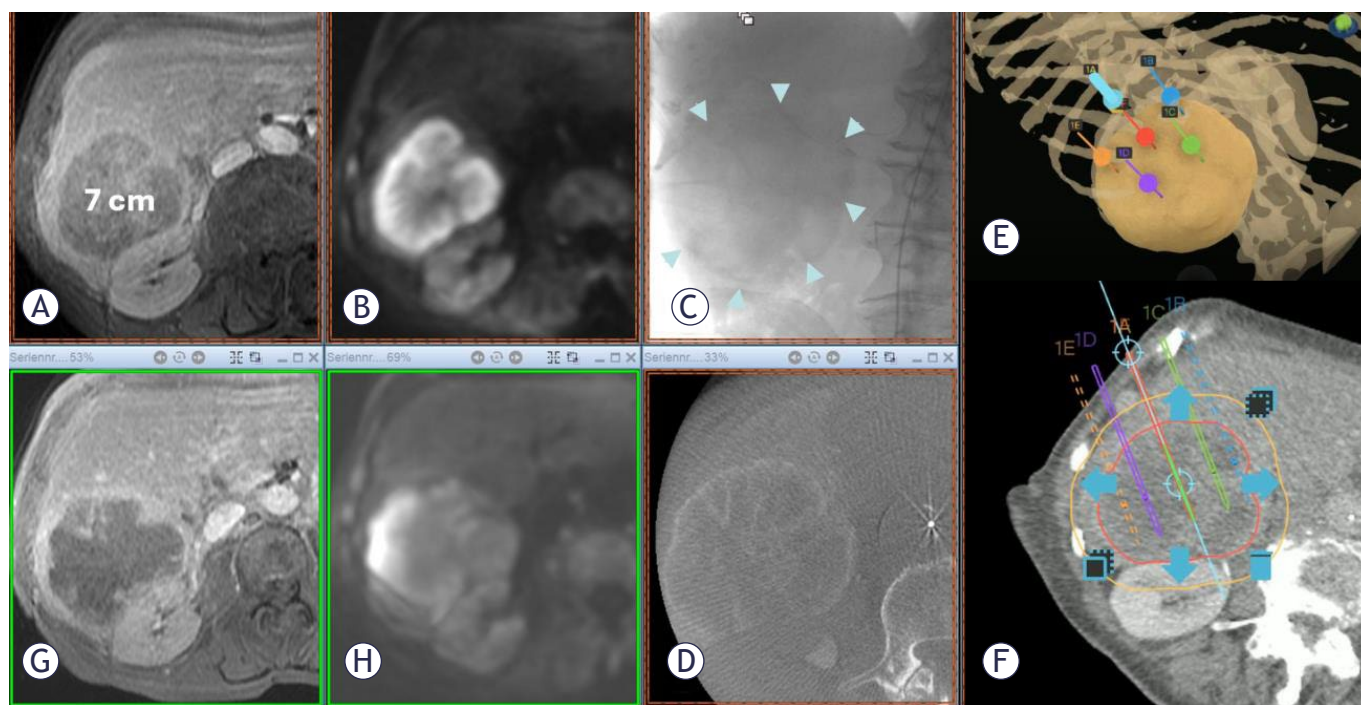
(A) Transverse contrast-enhanced T1w MR image of a pancreatic carcinoma metastasis with a maximum diameter of 7 cm in segments V/VI and VII, which no longer responds to systemic chemotherapy and is growing rapidly and progressively. (B) Corresponding slice to A in diffusion imaging. (C) Complete contrast of the metastasis in 2D angiography. (D) Documentation of complete contrast coverage of the metastasis in cone beam CT. (E). Stereotactic navigation (CAS-One® IR) of the electrodes for electroporation. (F). Parallel planning of the electrodes in the tumor to achieve homogeneous electroporation. (G). The transverse contrast-enhanced T1w MR image of the metastasis one month after the electrochemotherapy (ECT) procedure demonstrates the complete loss of perfusion in the entire metastasis. (H) Corresponding slice to G in diffusion imaging.
